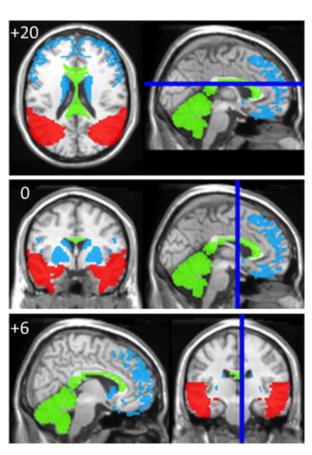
A summary of ASD and ADHD structural MRI findings. Light blue indicates regions where ASD predominately shows volumetric increases compared to controls and ADHD shows decreases; these regions include the prefrontal cortex and basal ganglia. Green indicates regions where ASD and ADHD display similar abnormalities including cerebellum and corpus callosum. Red indicates regions implicated predominately in ASD. These regions include the amygdala and temporal lobe.
